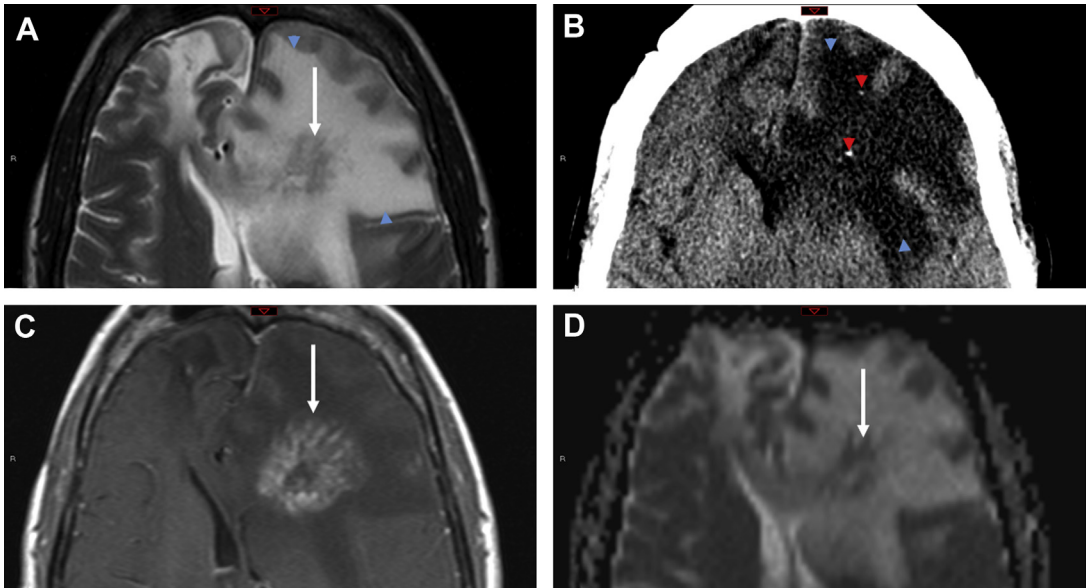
TREX1-associated retinal vasculopathy with cerebral leukodystrophy. Axial T2-weighted MR image, axial noncontrast CT scan, axial postcontrast T1-weighted image, and axial ADC map MR image in a 45 year old presenting with headache and weakness. Extensive left frontal vasogenic edema (*blue arrowheads* in *A* and *B*) surrounds an irregular mass-like area of periventricular enhancement (*white arrow* in *C*) with corresponding intermediate signal on T2 and ADC series (*white arrows* in *A* and *D*, respectively). A few punctate foci of calcification are displayed on CT images (*red arrowheads* in *B*). A nearly identical lesion was previously present in the right frontal lobe (not shown) with biopsy revealing subacute infarction with extensive gliosis and nonspecific vasculopathy.
